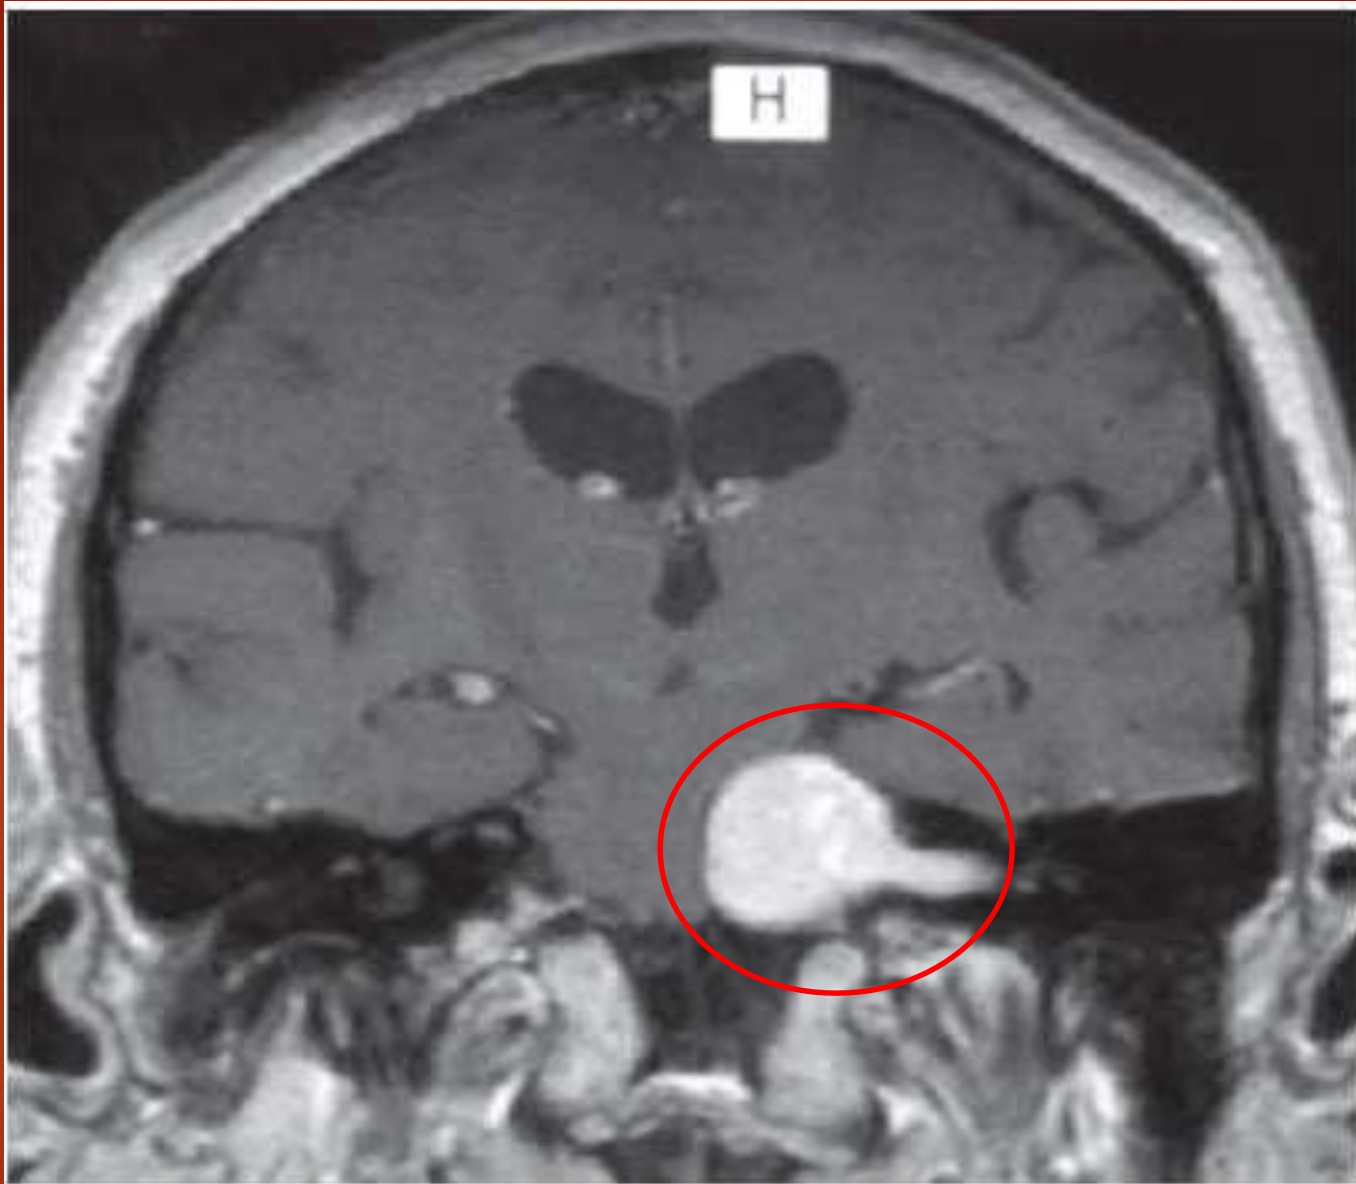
MRI with gadolinium enhancement – coronal image of an acoustic neuroma
